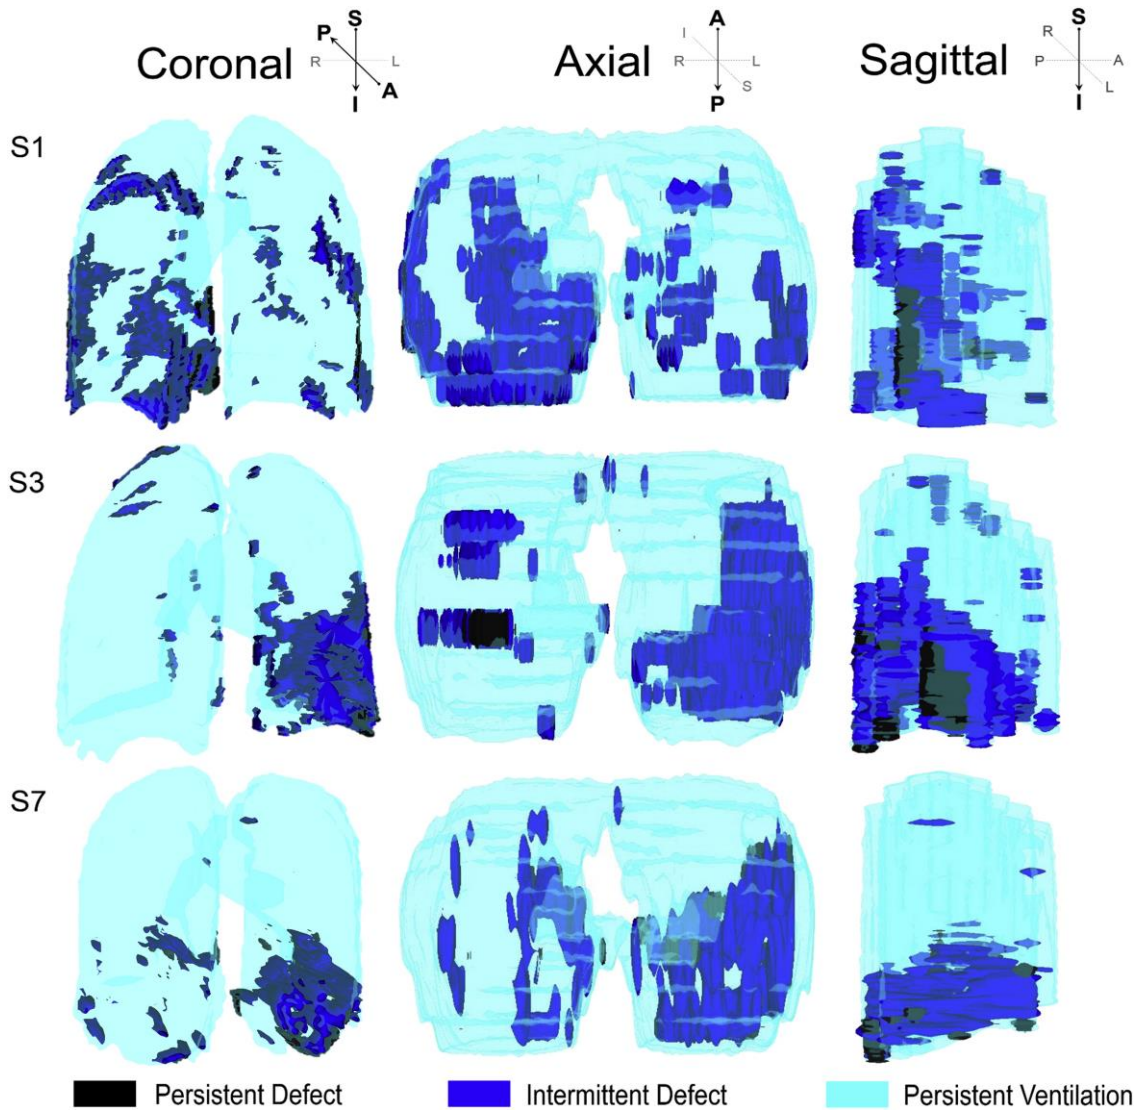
Three-dimensional ^3He MRI temporal-spatial pulmonary function maps for three representative asthmatic subjects.
